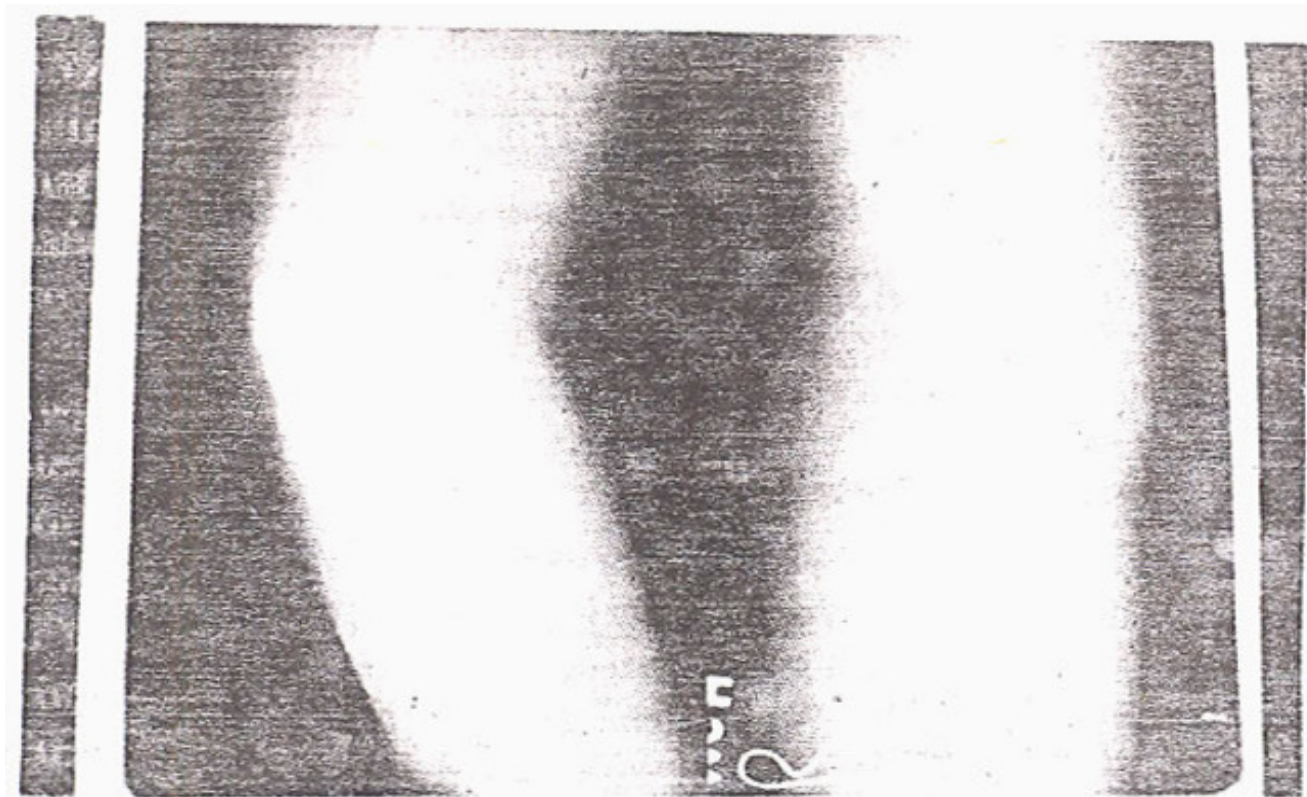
The destructive lesion in the lateral condyle of the humerus has smooth well defined margins, gout must be considered if such a lesion is noted, on a radiograph.
